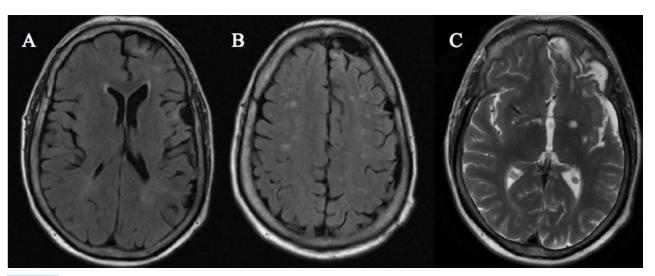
MRI imaging of patient done thirty years post injury. Panels A and C demonstrate significant left frontal atrophy. Panel B shows evidence of sub-cortical white matter residual lesions resultant from the TBI. In combination, these three panels represent the diffuse atrophy of the brain via encephalomalacic changes in left frontal, temporal, and parietal lobes as well as mild left ventricular dilatation.
